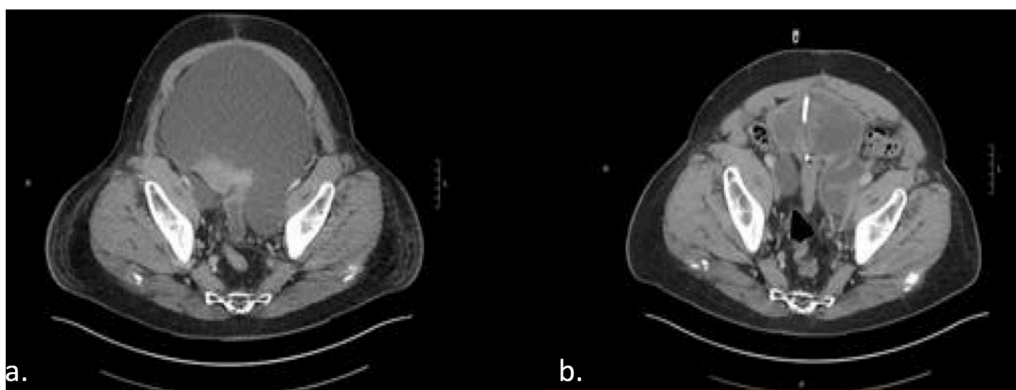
CT Images a) Large complex fluid collection with likely clotted blood products contained within the space of Retzius and compressing the iliac vessels b) Mildly improved but persistent complex fluid collection, again with clotted blood products, following drain placement.
